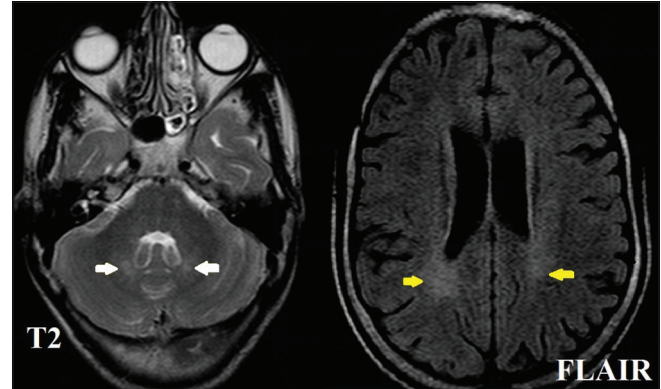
T2 and FLAIR axial section of magnetic resonance imaging demonstrate dentate nuclei hyperintensity (white arrows) and peritrigonal white matter hyperintensities (yellow arrows), respectively.
